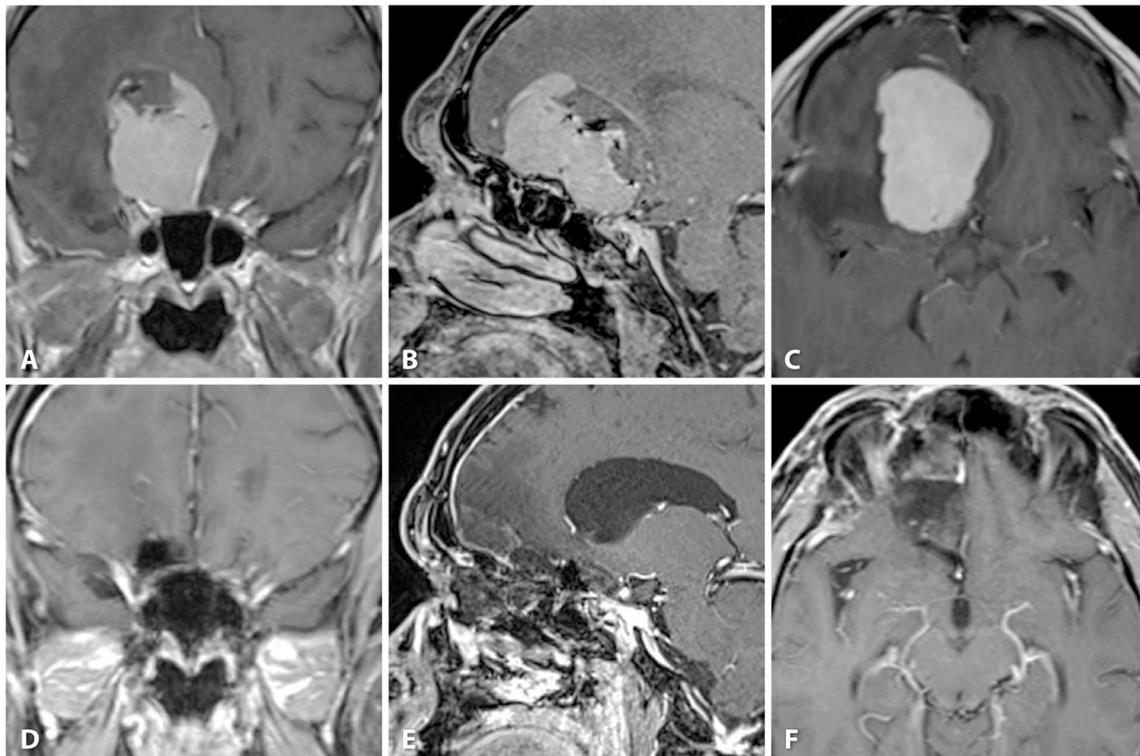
a–c T1-weighted triplanar MRI with contrast medium demonstrating a large right frontobasal and olfactory groove meningioma. d–f MRI 3 months postoperatively demonstrating complete tumor resection
